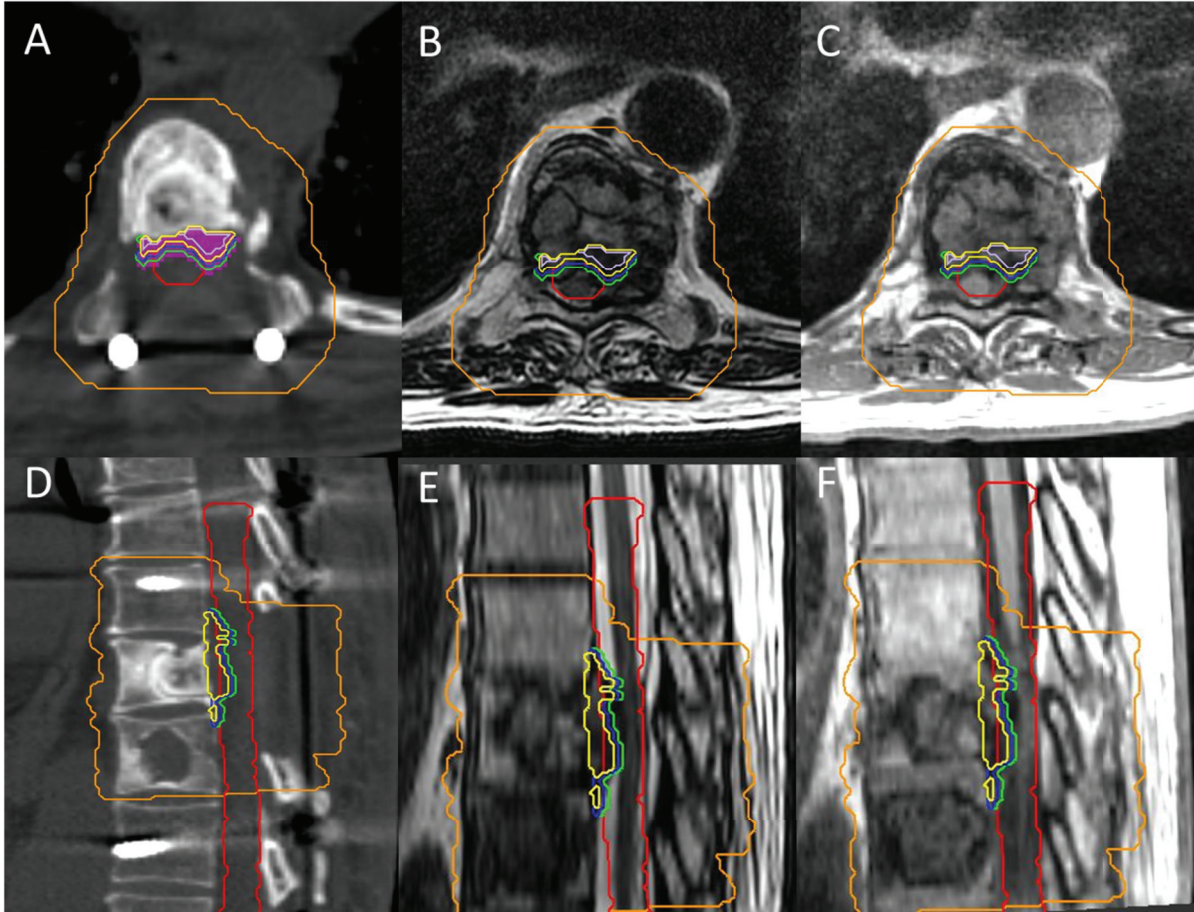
Post-surgical Dose Distribution: T9 vertebral body post laminectomy and cord decompression/tumour resection. A,D) Axial and sagittal CT image of the vertebral body with bilateral inserted pedicle screws. Planning target volume encompasses entire vertebral body (orange). Outline of the spinal cord shown in red with epidural-GTV (purple colorwash) and incremental millimeter epidural disease contours (green – 1 mm, blue – 2 mm, yellow – 3 mm, lavender – 4 mm). B,E) T2 MRI image used for fusion and epidural disease contouring. C,F) T1 MRI image used for fusion and epidural disease contouring.
